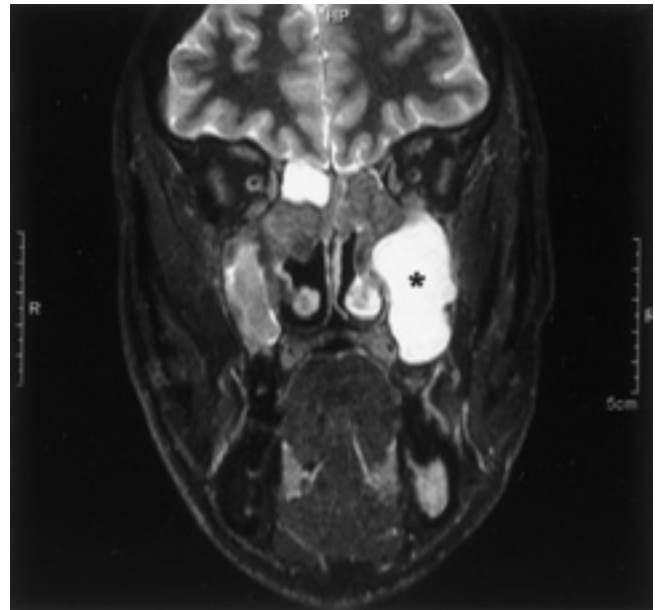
MRI in T2 showing a hyperintense signal (mucocele) in the right ethmoid and the left maxillary sinus (asterisk).
